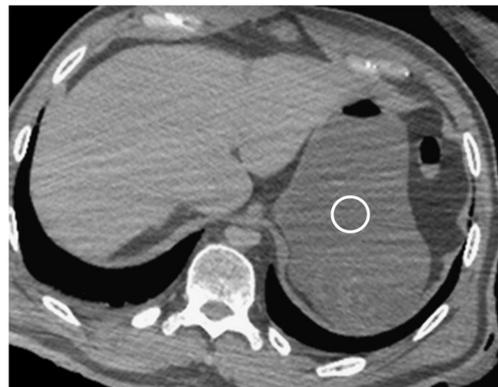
Post-mortem axial CT scan of the upper abdomen in parenchymal window. The ROI placement for measuring the density of the gastric contents is indicated
